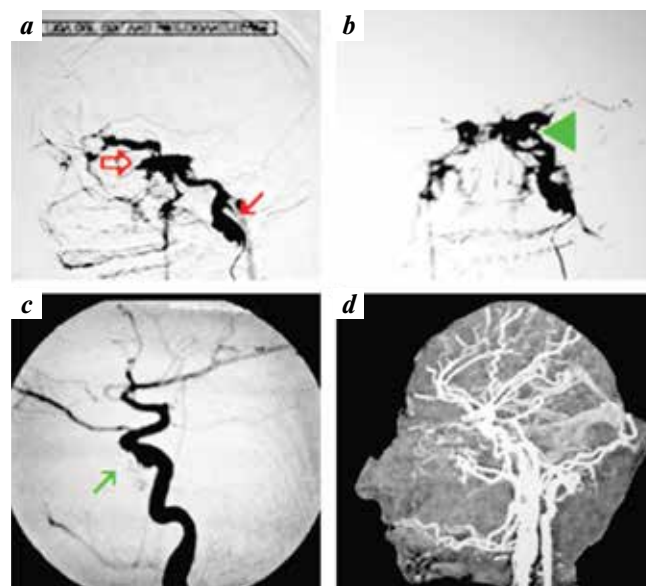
Depicting DSA lateral view showing two pseudoaneurysms (arrows) arising from cervical internal carotid artery, carotid cavernous fistula (a); depicting DSA AP view showing carotid cavernous fistula (arrow head) with bilateral cavernous sinus filling (b); depicting DSA lateral view of internal carotid artery following carotid cavernous fistula coiling and pseudo-aneurysm stenting (oblique arrow), showing distal flow in branches (c); depicting CT angiography lateral view after complete treatment, showing complete recovery (d)
